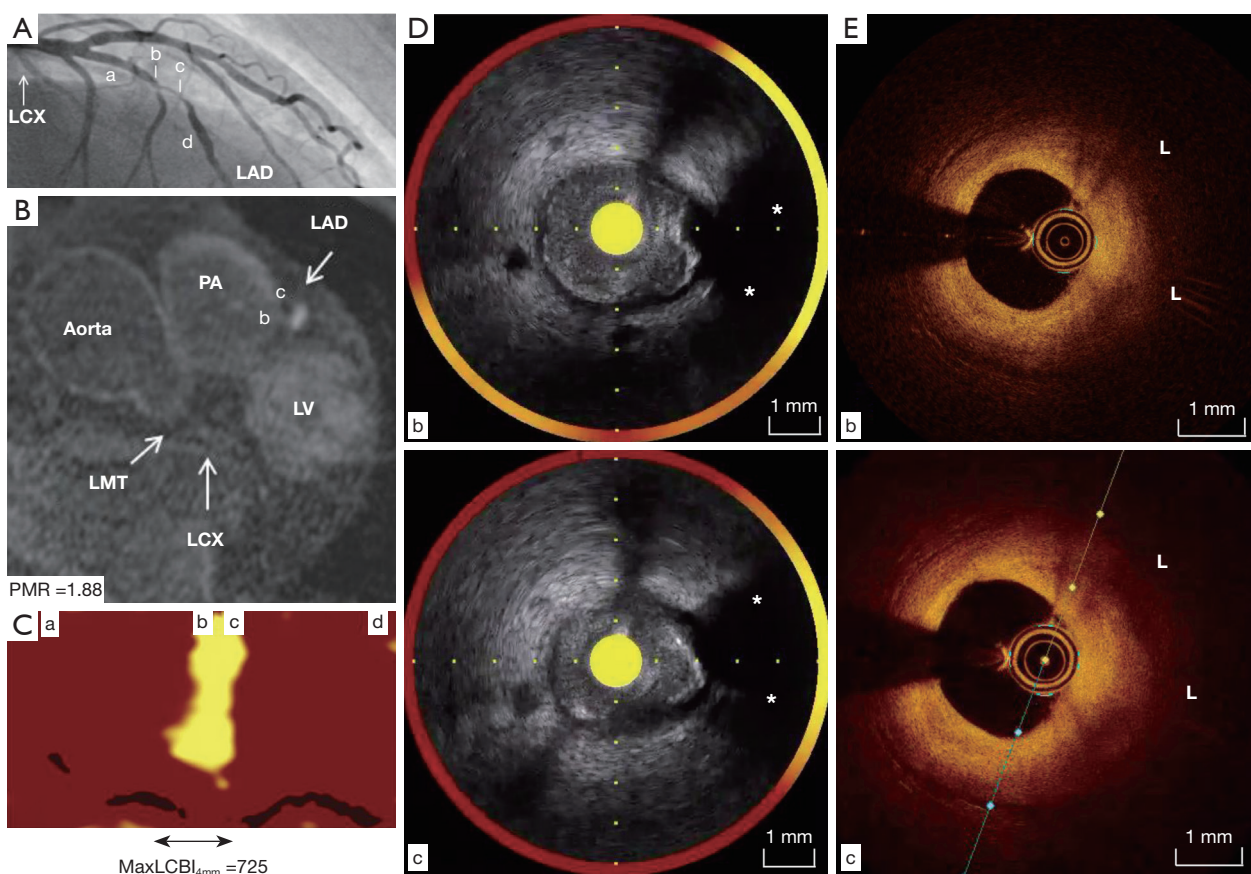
Imaging of culprit lesion in case 2. (A) Coronary angiography: a severe stenosis in the middle segment of LAD artery was observed (b and c). a-d correspond to those in (C-E). (B) Non-contrast T1WI: non-contrast T1WI identified the presence of high-intensity signal at the corresponding lesion of LAD artery. Its PMR was 1.88. (C,D) NIRS/IVUS imaging: on NIRS/IVUS imaging, maxLCBI_{4mm} was 725 at culprit site. Ultrasonic signal attenuation (asterisk in b) was identified (c). (E) OCT imaging: lipid-rich plaque (L) without any thrombus was observed at the corresponding site on OCT (b and c). LCX, left circumflex artery; LAD, left anterior descending; LMT, left main trunk; PA, pulmonary artery; LV, left ventricular; PMR, plaque-to-myocardial signal intensity ratio; maxLCBI_{4mm}, maximum 4-mm lipid core burden index; T1WI, T1-weighted imaging; NIRS, near-infrared spectroscopy; IVUS, intravascular ultrasound; OCT, optical coherence tomography.
